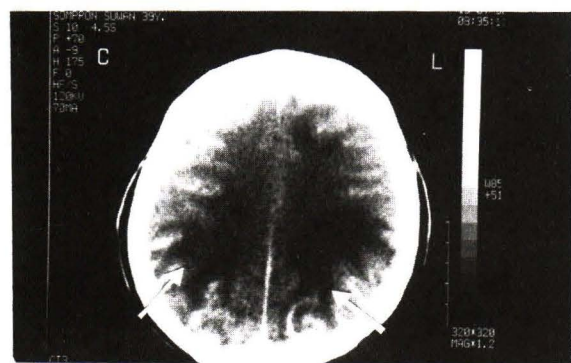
Postcontrast axial CT scan at an upper level exhibited more diffuse white matter oedema and increased both gyriform and sulcal enhancement bilaterally.
